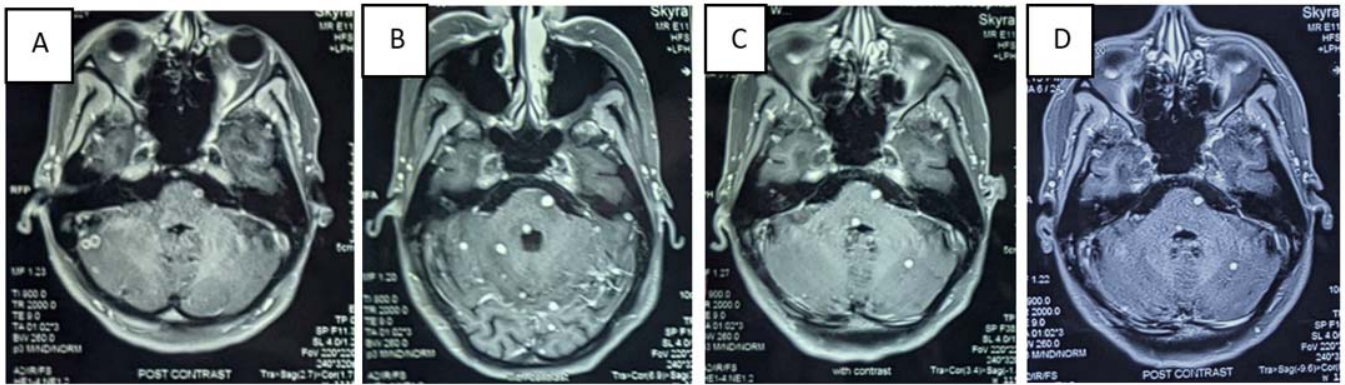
Contrast T1 MRI brain (A) at diagnosis; (B) at six weeks; (C) at 10 weeks; (D) at 18 weeks of antituberculosis treatment.
